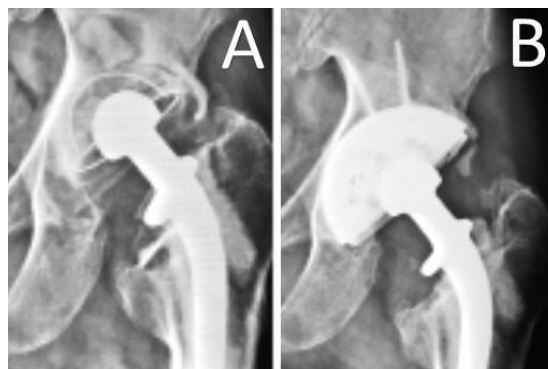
Revision of failed acetabular socket with jumbo cup. A: preoperative and B: post-operative x-ray⁽⁵⁵⁾.
